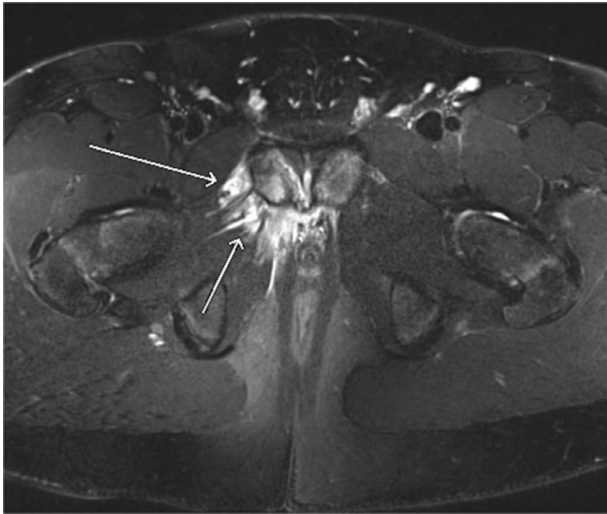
Axial T2 fat-saturated postgadolinium MRI demonstrates edema and intramuscular tears involving the right obturator internus and externus muscles and mild widening of the right pubic bone apophysis with edema at the superior ramus. MRI, magnetic resonance imaging.
